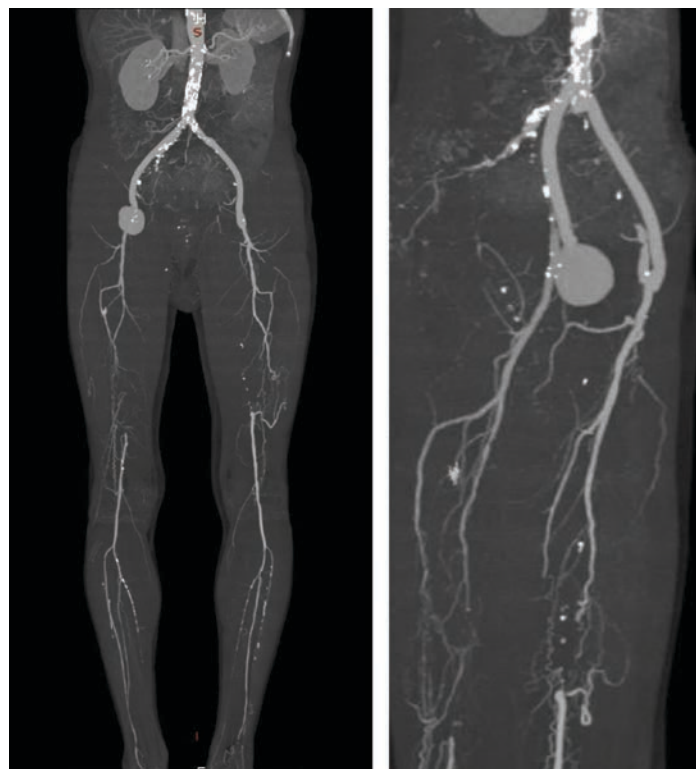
Case example of a patient with critical limb ischemia and right femoral pseudoaneurysm after multiple revascularizations seen on computed tomography angiography images.
